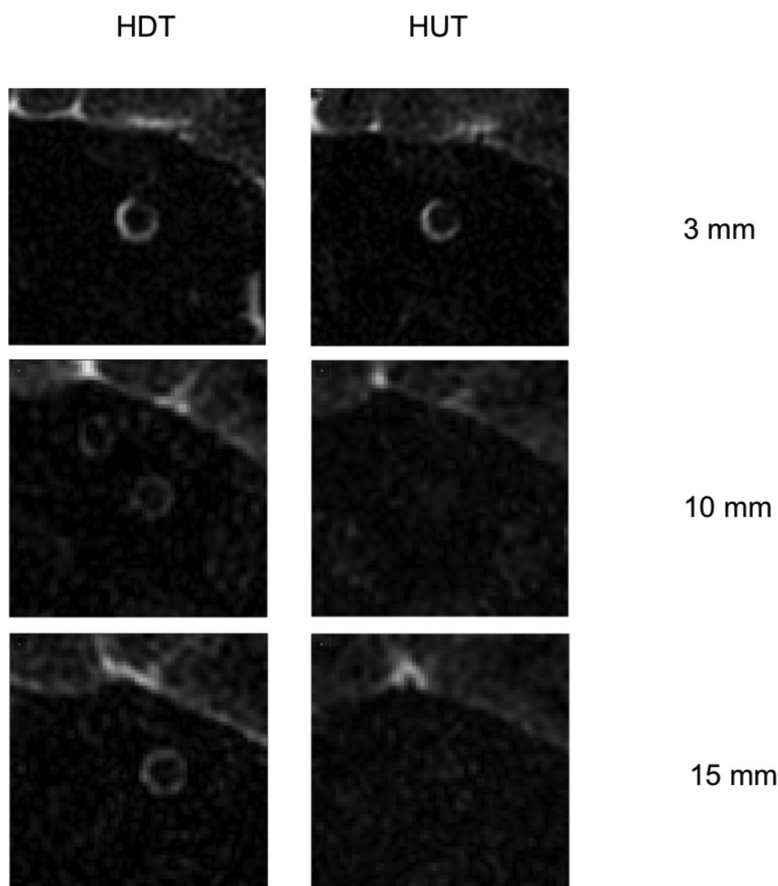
MRI of the ONSAS in a second subject in HDT and HUT 3, 10, and 15 mm behind LC. In HUT, the ONSAS is visible in the bulbar region only.
